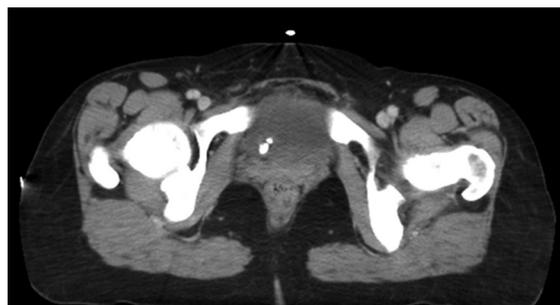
Computed tomography imaging reveals distal ureteral stones.hdoi.
